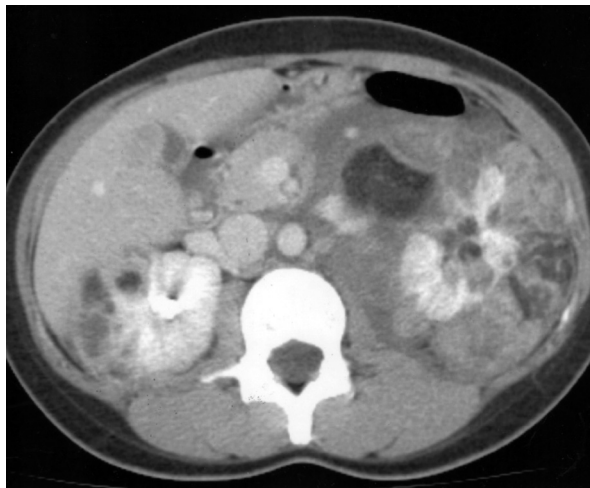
Abdominal CT showed 2 heterogeneous masses in both kidneys with blood clot accumulation around the left kidney.
